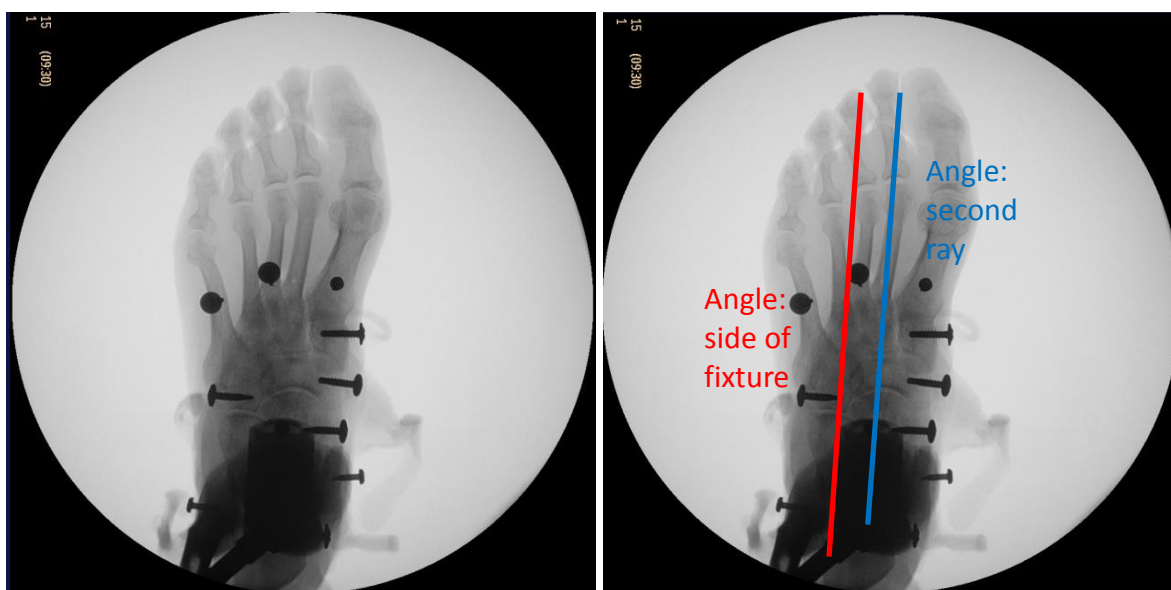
(Left) Superior-Inferior radiograph to determine neutral transverse plane alignment, using the screwdriver to press on the tibia to get hands out of the fluoroscope field (Left). The goal is to line up the fixture parallel to the second ray, measured by lining up the side of the fixture parallel to the axis of the second ray (Right). If the second metatarsal is adducted and the second toe is abducted, only the second metatarsal was used for alignment, or the different was split in extreme cases.
